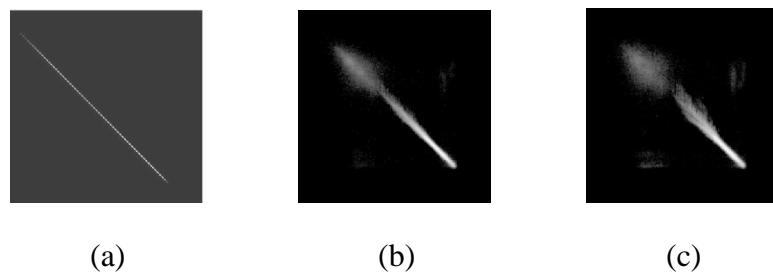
Joint histogram images where values found in the reference image are placed over the abscissa axis and those from the moving image are placed on the ordinate axis. The joint histograms were created from identical CT images, perfectly aligned in (a) and with a rotation R applied to one of the images, $R = 5$ (b) and $R = 10$ (c).
